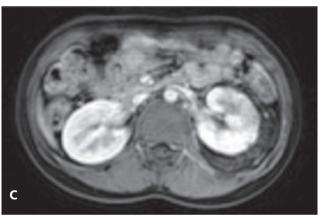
A) Hyperintense left perirenal cystic lesion infiltrating renal parenchyma on coronal T2 weighted magnetic resonance image, B) Hyperintense left perirenal multiple cysts on axial T2 weighted image, C) Axial post-contrast T1 fat-suppressed image showing hypointense and non-contrast enhancing left perirenal cysts
